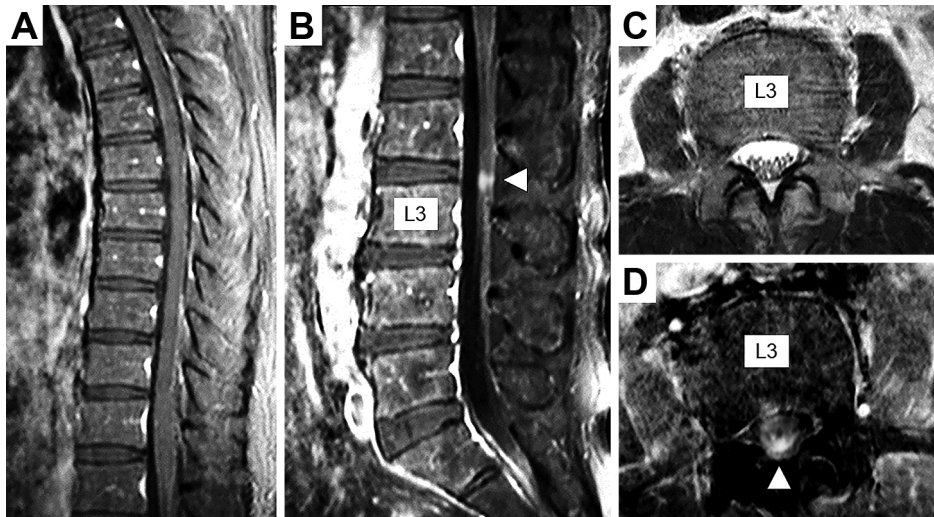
Spinal magnetic resonance imaging (MRI) on day 1 after admission.
